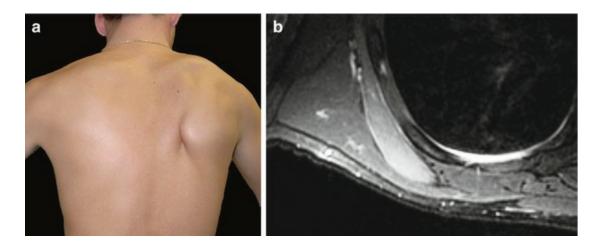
A football (soccer) goalkeeper following a fall on the apex of the shoulder and resultant right long thoracic neuropathy. (a) Photograph of the patient shows medial winging of the right scapula. (b) Axial fat-suppressed MRI confirms the diagnosis and reveals edema of the right anterior serratus muscle
